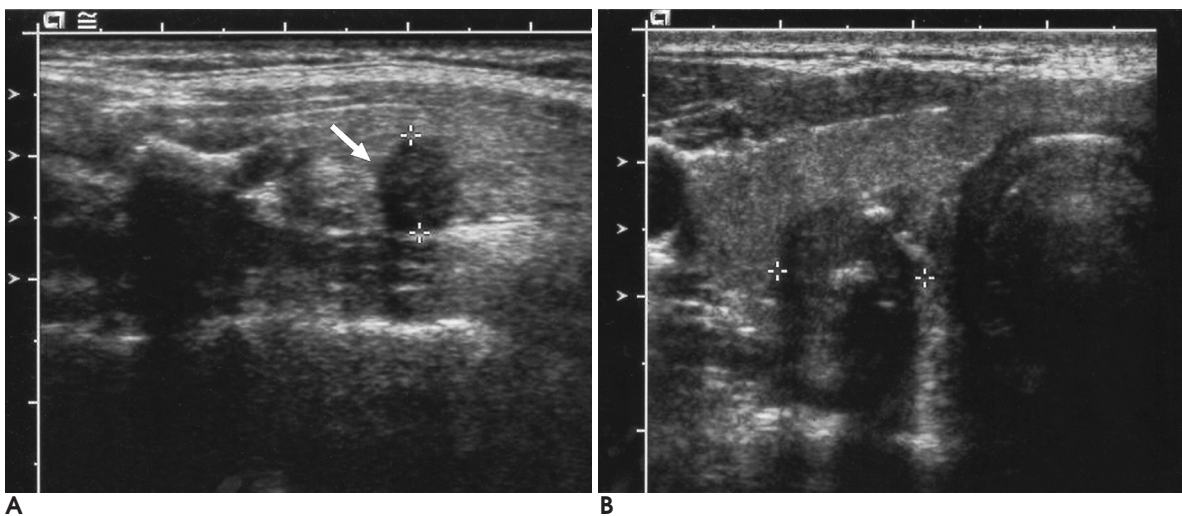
Sonographic features that are suggestive of malignant thyroid nodules.
